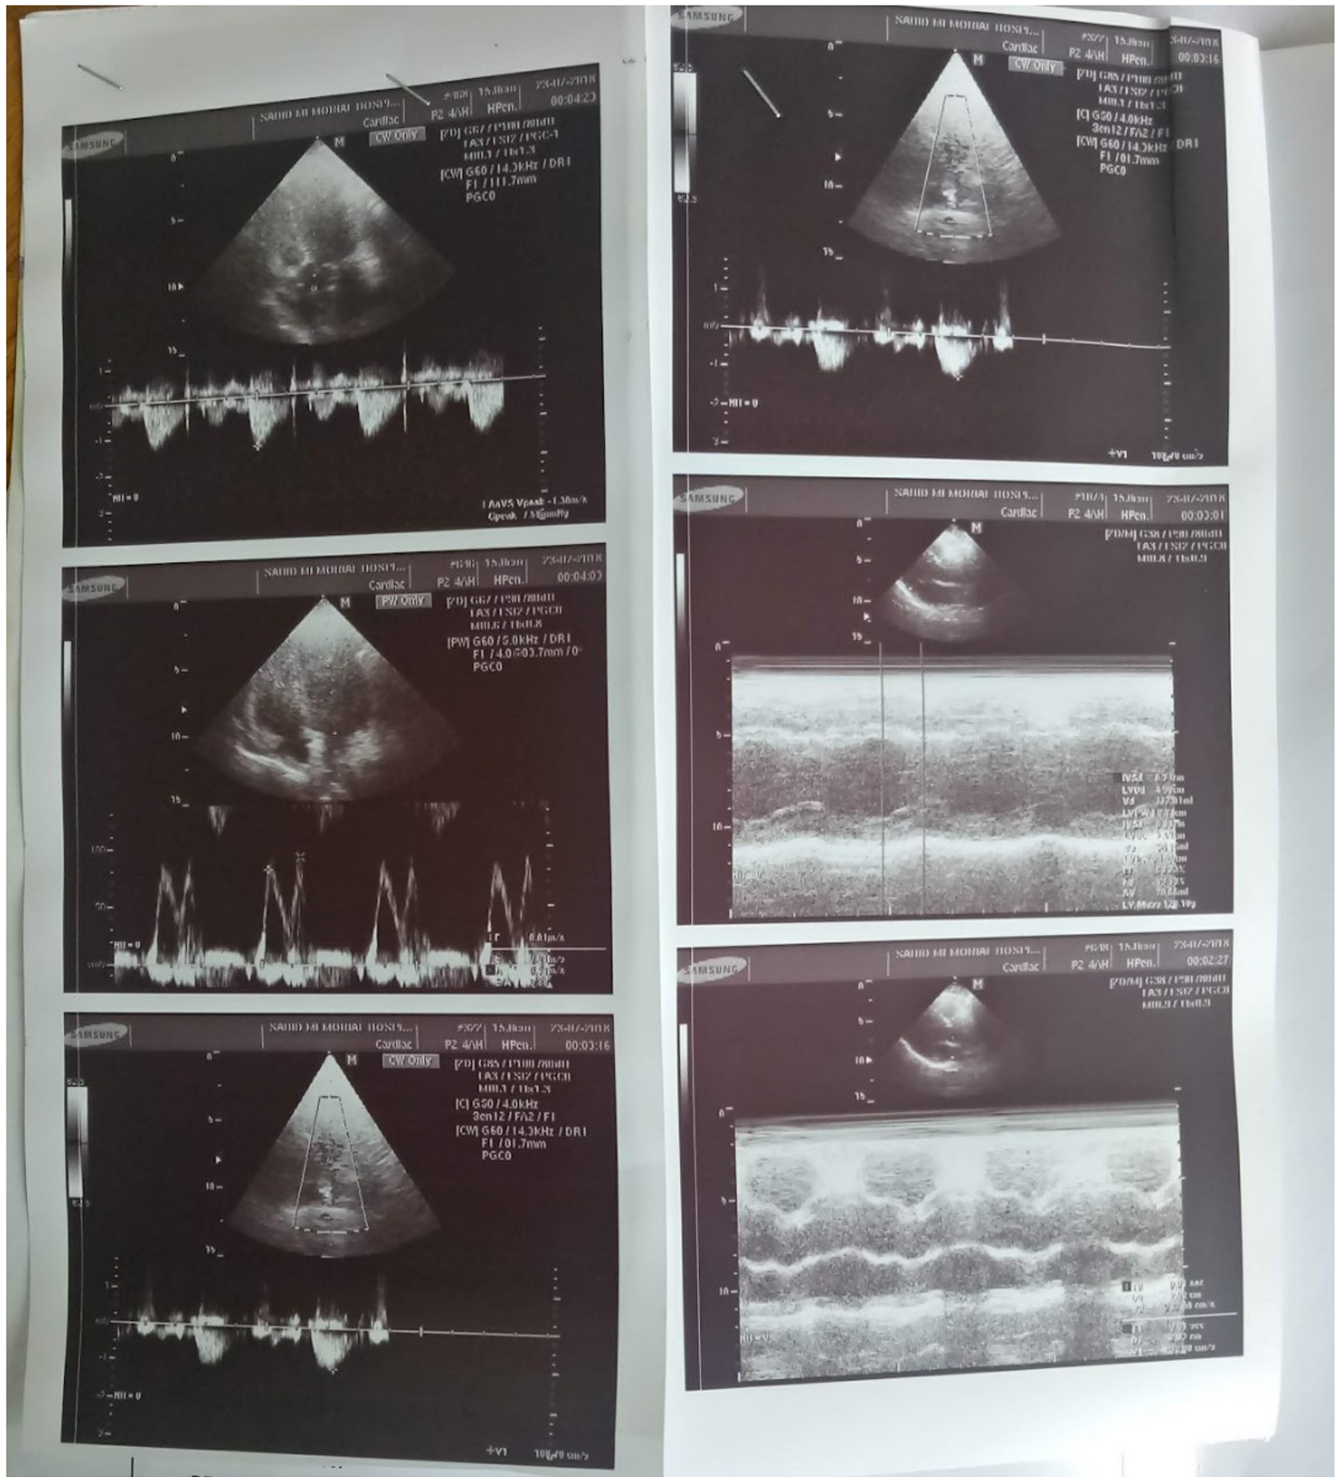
Echocardiography
